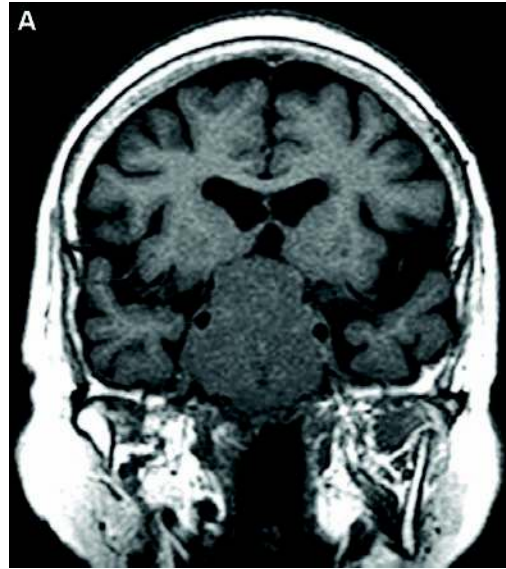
A,B,C: MRI appearance of a macroadenoma. (A) (Coronal) and (B) (Sagittal). (C) The tumor shows a marked enhancement.
